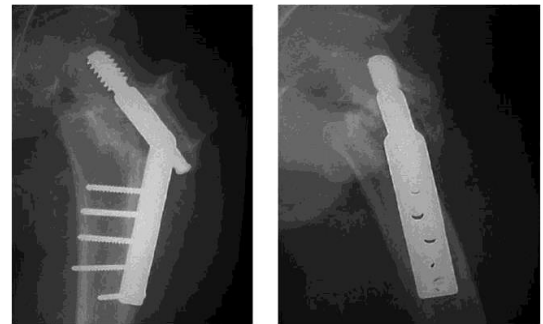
>4 mm of displacement on lateral X-ray; >20 degrees of angulation on the lateral X-ray: Poor reduction
